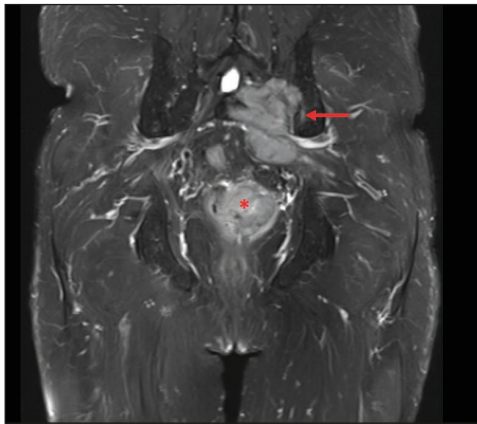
Fat suppressed coronal T2 magnetic resonance imaging sequence: metastasis (red arrow), and prostatic lesion (red asterisk) compatible with the primary tumoral lesion are visible.
